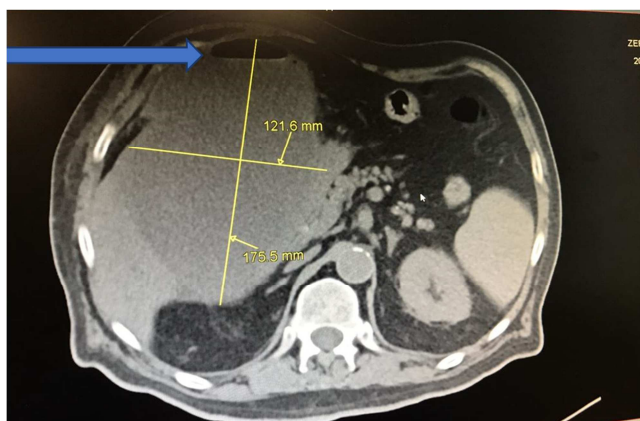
Axial cross-sectional abdominal CT scan showing a large gallbladder with air bubbles in the bladder wall.
